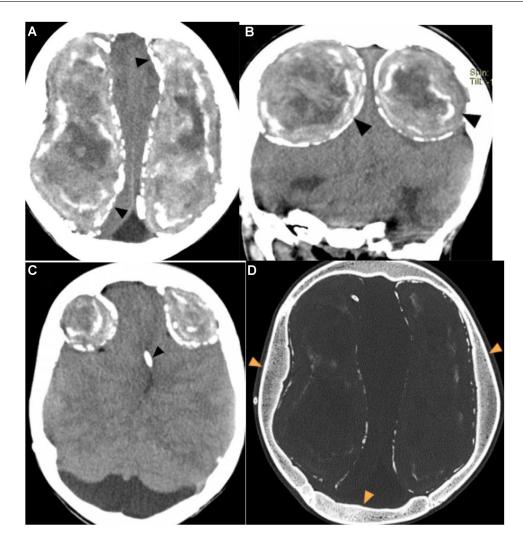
Noncontrast brain CT in axial (A) and coronal (B) sections show large bilateral calcified chronic subdural hematoma of the frontoparietal convexity (black arrowheads in A and B) and a bilateral trans tentorial herniation. A VP shunt catheter in a narrowed lateral ventricle (black arrowhead in C) and diffuse calvarial thickening (yellow arrowheads in D) are seen.
